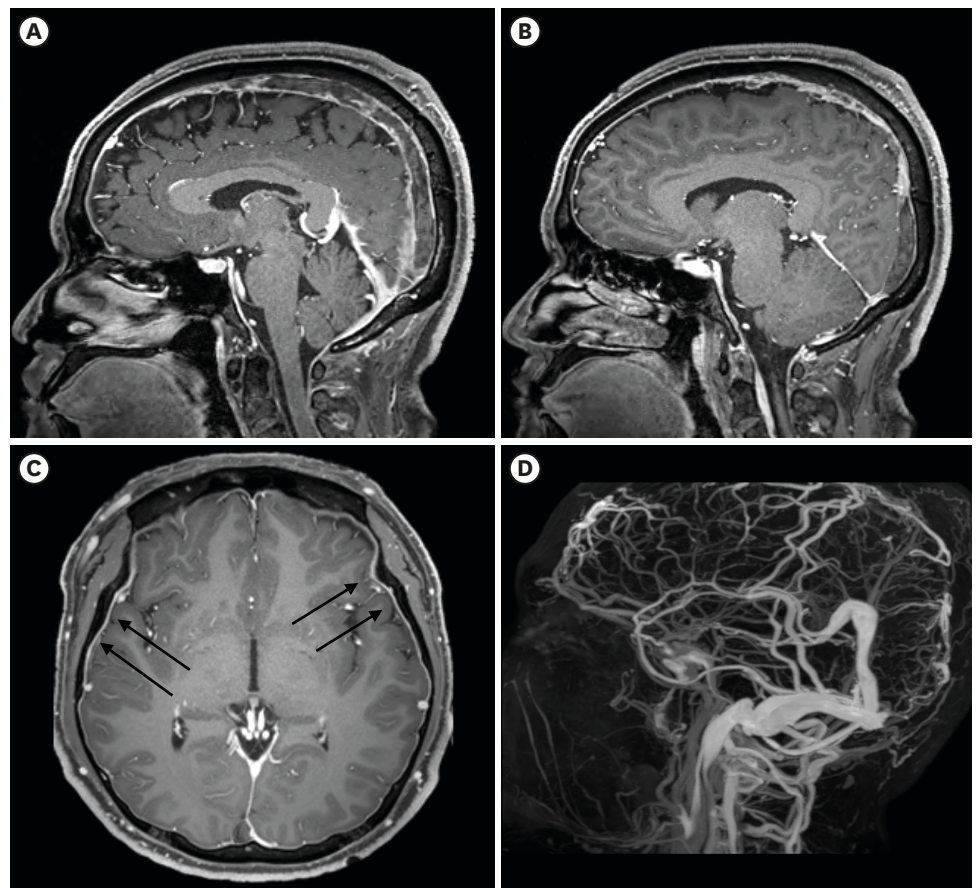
Brain magnetic resonance imaging. T1 gadolinium-enhanced imaging sagittal views (A & B), axial view (C) and MR venography (D). (A & B) Filling defects in sagittal and transverse sinuses are shown. (C) Black arrows indicate diffuse pachymeningeal thickening. (D) MR venography reveals non-visualization of the superior sagittal sinus. MR: magnetic resonance.
